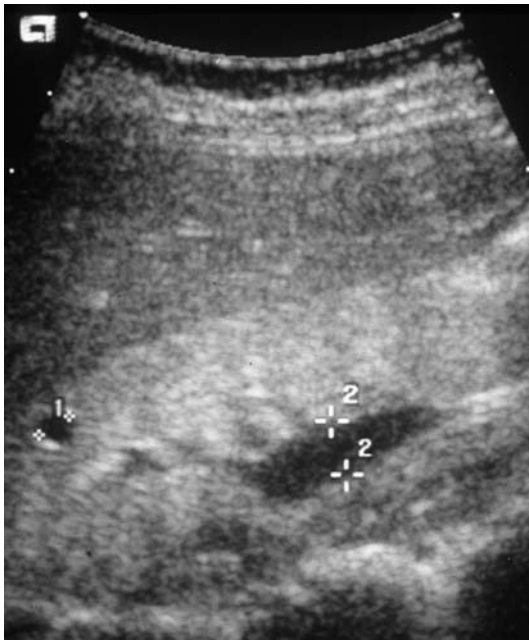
Renal ultrasonography in patient III-1 at 9 years of age. Longitudinal view of the small echodense right kidney showing a dilated renal pelvis (++, 7 mm) and a cortical cyst (++, 4 mm)
